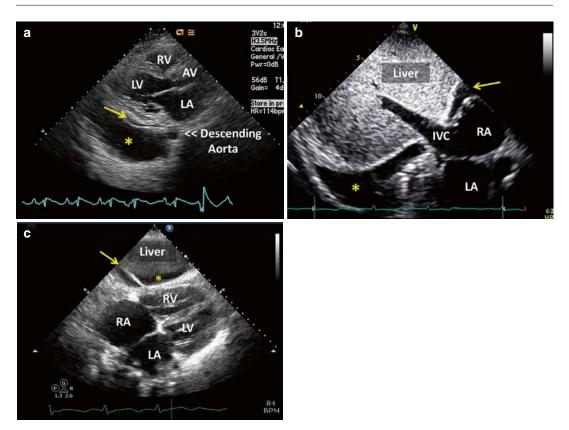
Differential diagnosis of a pericardial effusion. Panel a: Left pleural effusion – Transthoracic echocardiogram in the parasternal long axis view demonstrates a left pleural effusion (*asterisk*) and a very small pericardial effusion (*arrow*). Note that unlike the pericardial effusion, the left pleural effusion does not create an echo lucent area of separation between the descending thoracic aorta and the heart. Panel b: Right pleural effusion – Transthoracic echocardiogram in the subcostal view demonstrates a left pleural effusion (*asterisk*) and a pericardial
